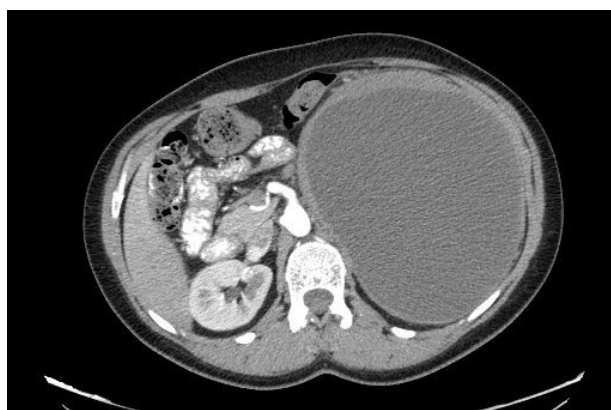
Retroperitoneal pseudocyst on computed tomography (CT) scan
